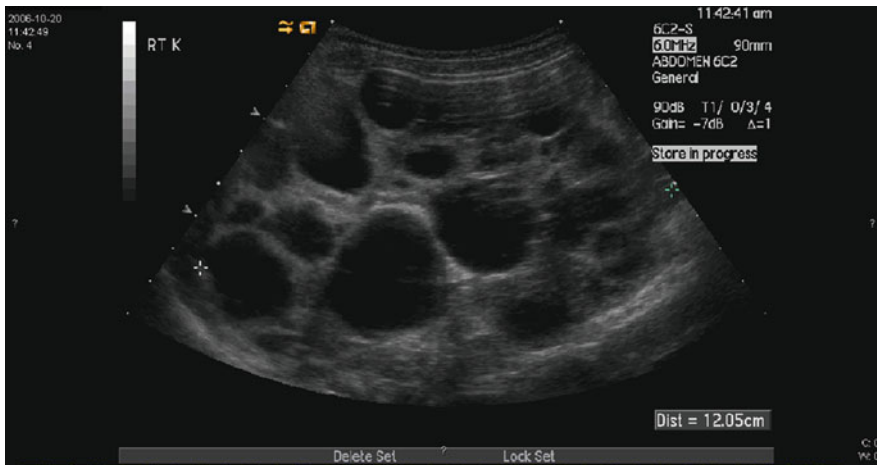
Renal ultrasound of the right kidney of a 1-month-old boy with ADPKD and severe hypertension.
